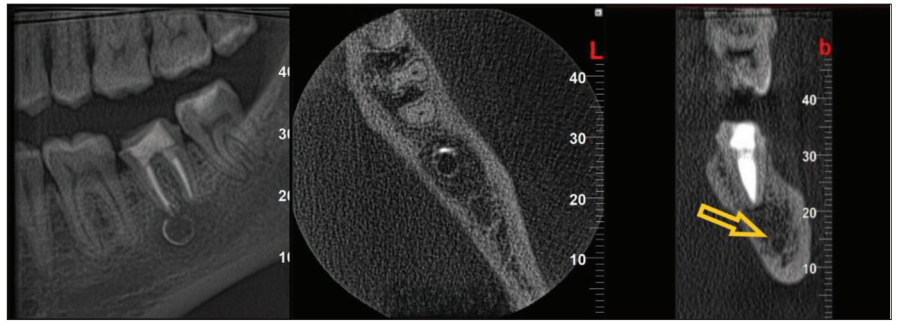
Representative sections from CBCT made one year after therapy: (a) coronal and (b) axial plane presenting reduction of diffuse lesion as well as calcification of the wall of central radiolucent lesion; (c) sagittal plane presenting newly formed mandibular canal roof
